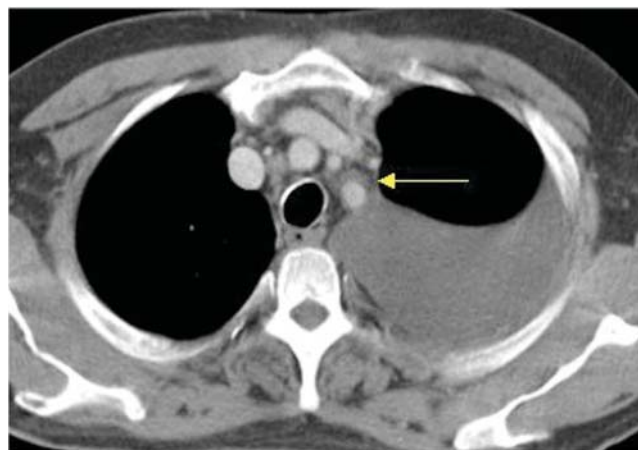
Chest computed tomographic scan shows left-side chylothorax secondary to lymphoma. Subtle mediastinal lymphadenopathy obstructing the thoracic duct (arrow) is apparent.
